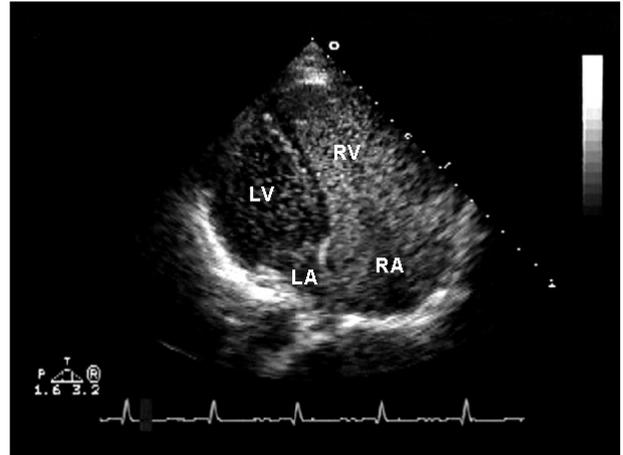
Modified apical 4-chamber view of two-dimensional contrast echocardiogram with peripherally injected contrast agent (hand-agitated saline). Contrast appearing in left atrium by pulmonary veins after delay.
